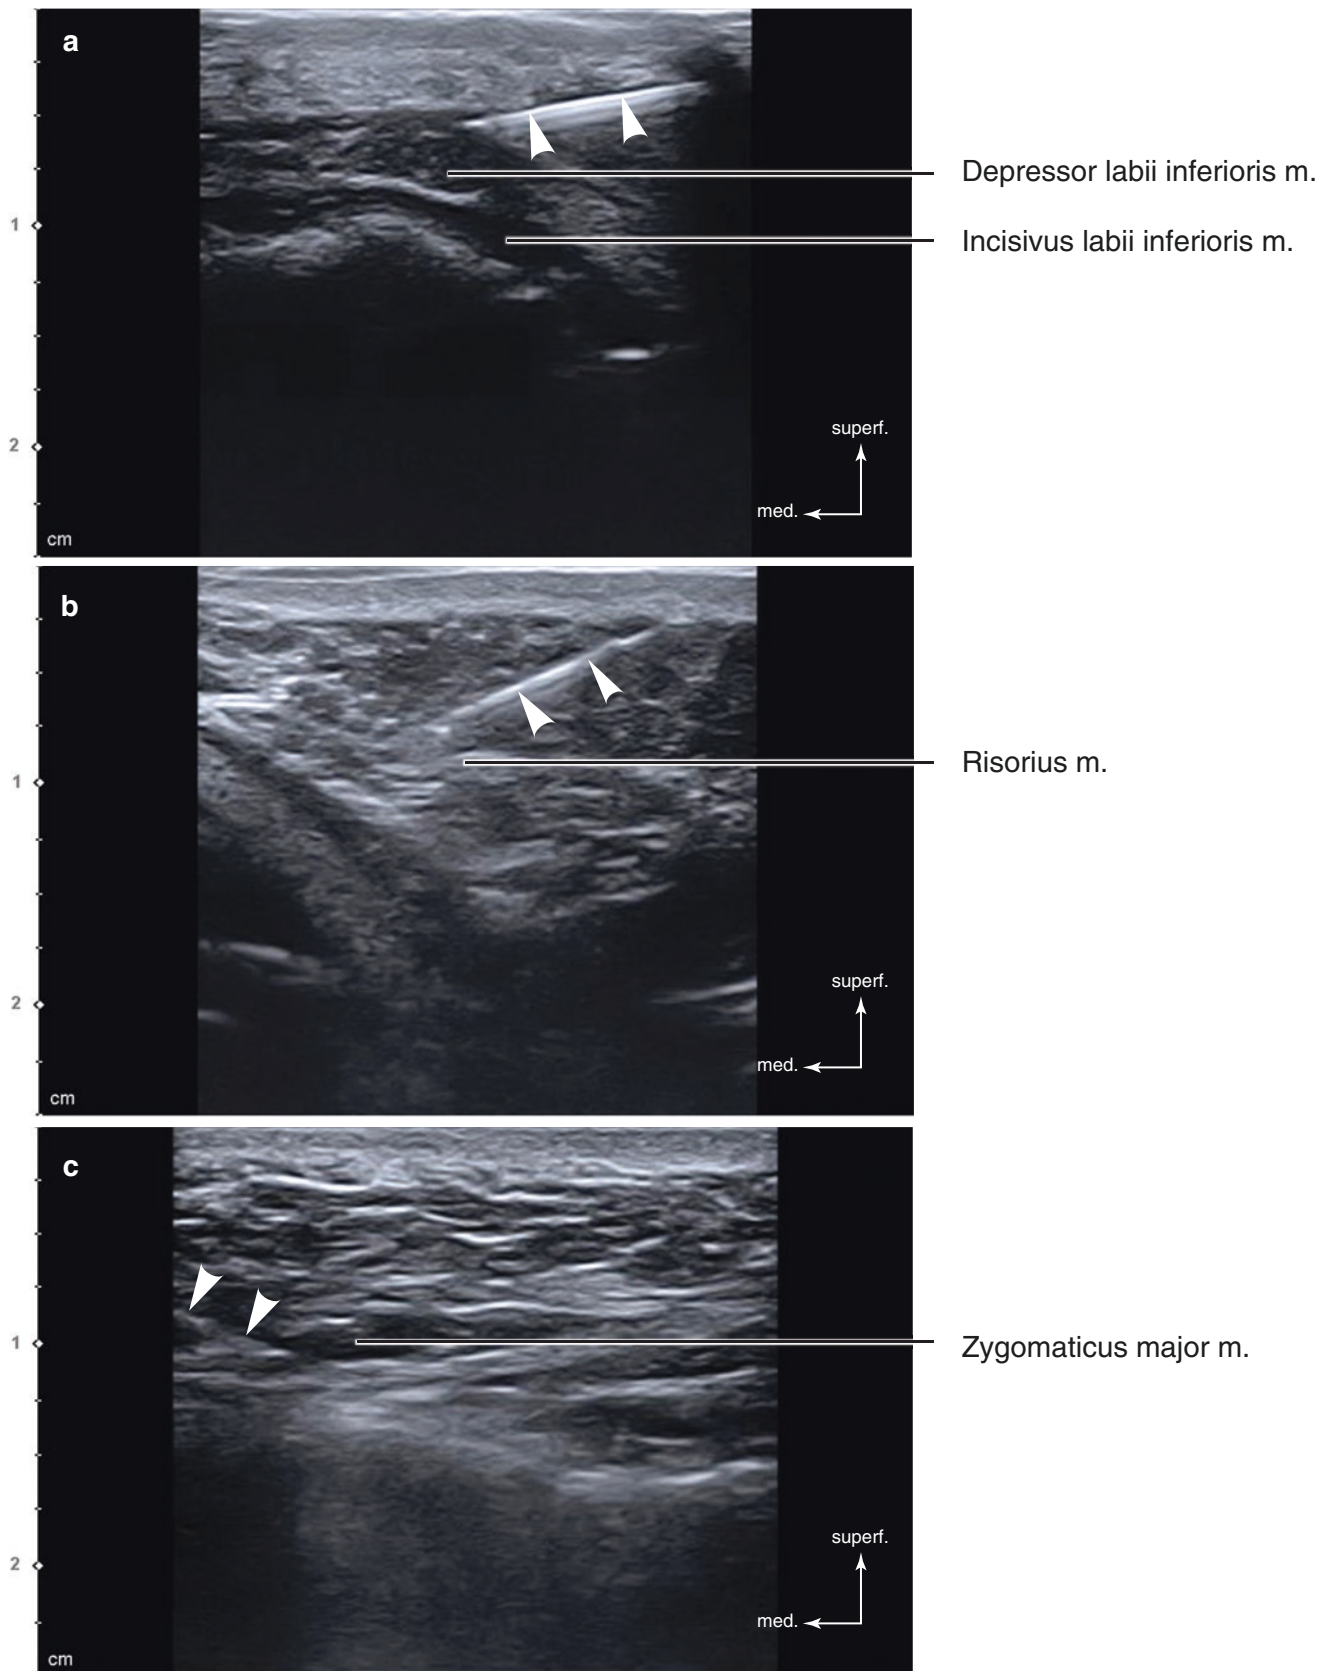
Ultrasonography-guided botulinum toxin injection to the perioral expression muscles (in-plane). (a–c) B mode (transverse view, 15 MHz by linear transducer) (white arrowheads: injection needle). (Published with kind permission of © Ji-Soo Kim 2020. All Rights Reserved)
